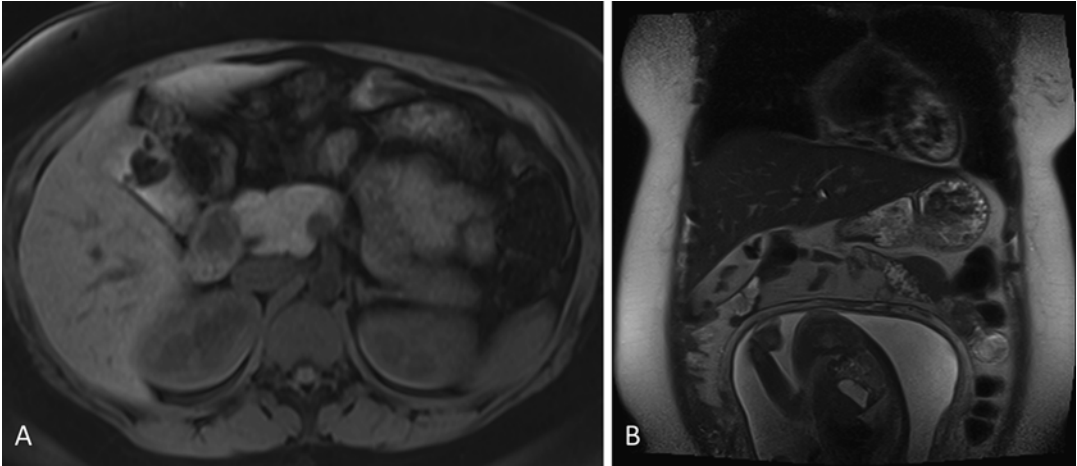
MRI scan of a pregnant female who presented with right upper quadrant pain and was found to have cholelithiasis. (a) Axial T1-weighted image. (b) Coronal T2-weighted image
